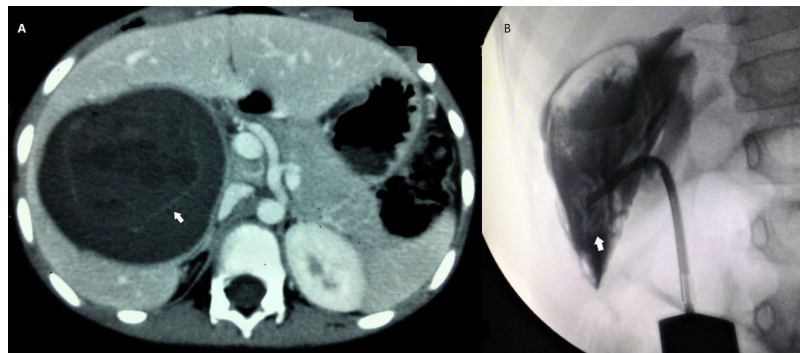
(A) Computed tomography showing large cyst in liver with water-lily sign (arrow) and areas of central hypoattenuation (daughter cysts). (B) PAIR procedure showing floating membranes (arrow).
